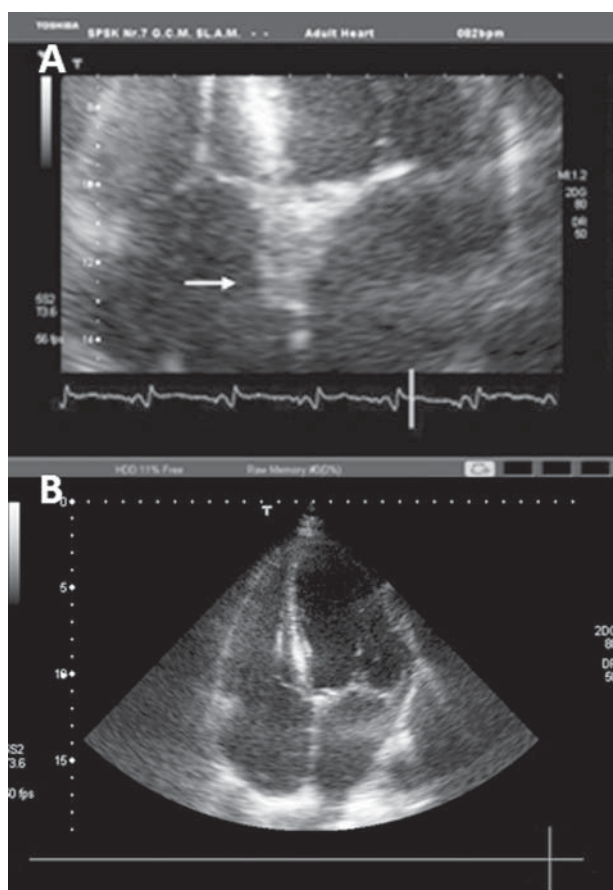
Transthoracic echocardiography — tumour localised within the right atrium and the right ventricle along inter-atrial septum; A. Four-chamber view; B. Zoom scan — tumour and pacemaker electrode
